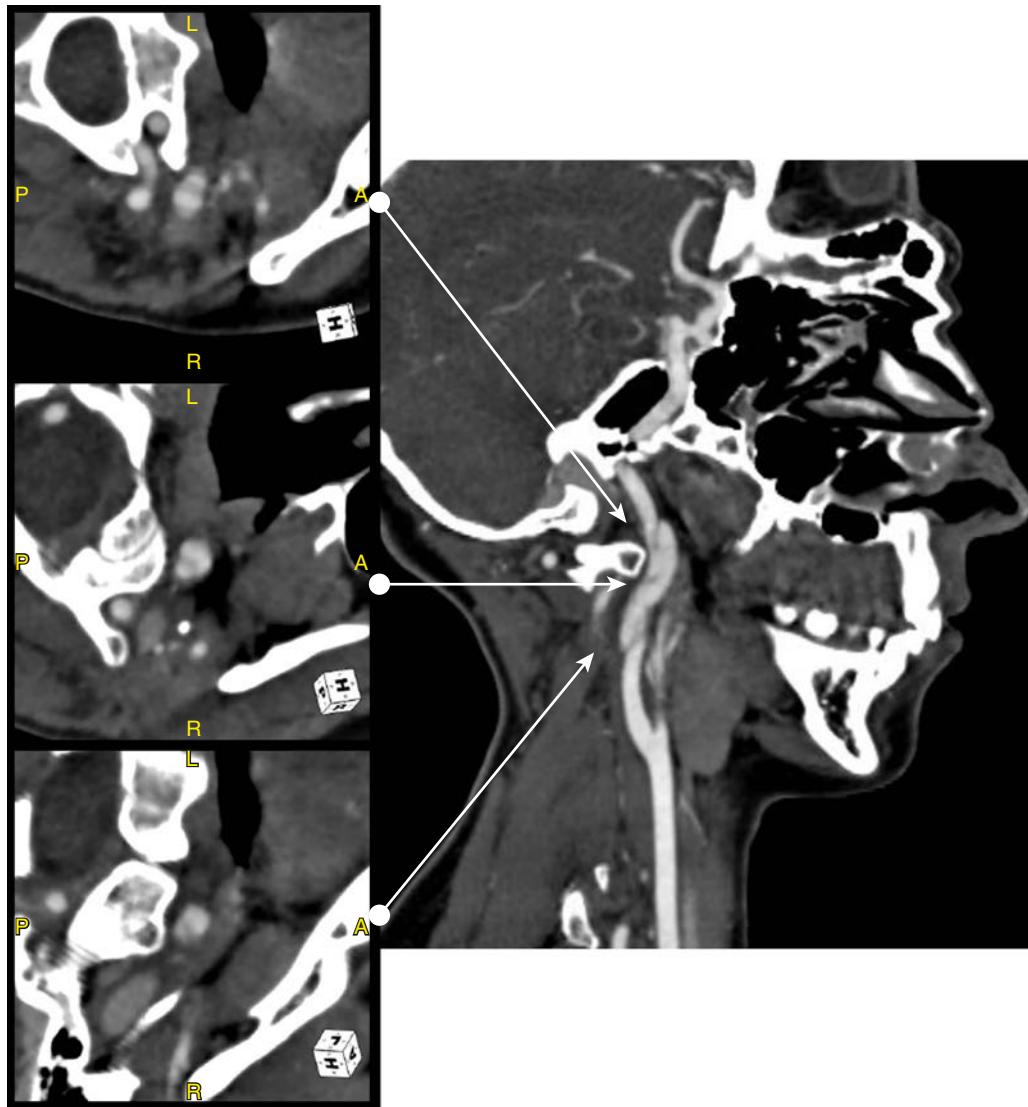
Penetrating vertebral artery injury secondary to a stab wound at the base of the left side of the neck. CT angiography demonstrates serial slices showing both a pseudoaneurysm as well as a dissection.
